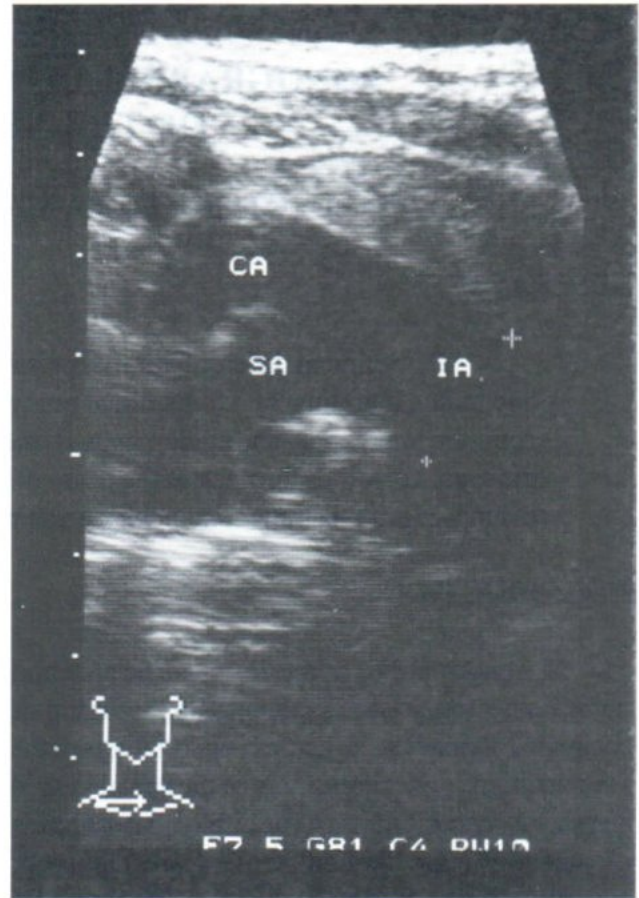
Transverse sonogram of right supraclavicular fossa demonstrates buckled common carotid artery (CA). IA = innominate artery, SA= subclavian artery
